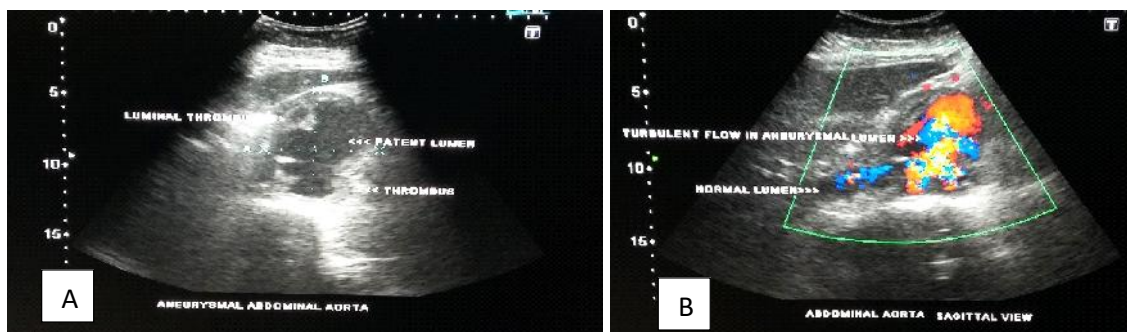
A) 2-dimensional ultrasound image of the abdomen of a 52-year-old female showing the largest aneurysm with a multiple eccentrically located intraluminal thrombi. B) Doppler examination shows the blood flow within the normal lumen of the aorta and turbulent flow in the aneurysmal lumen.
